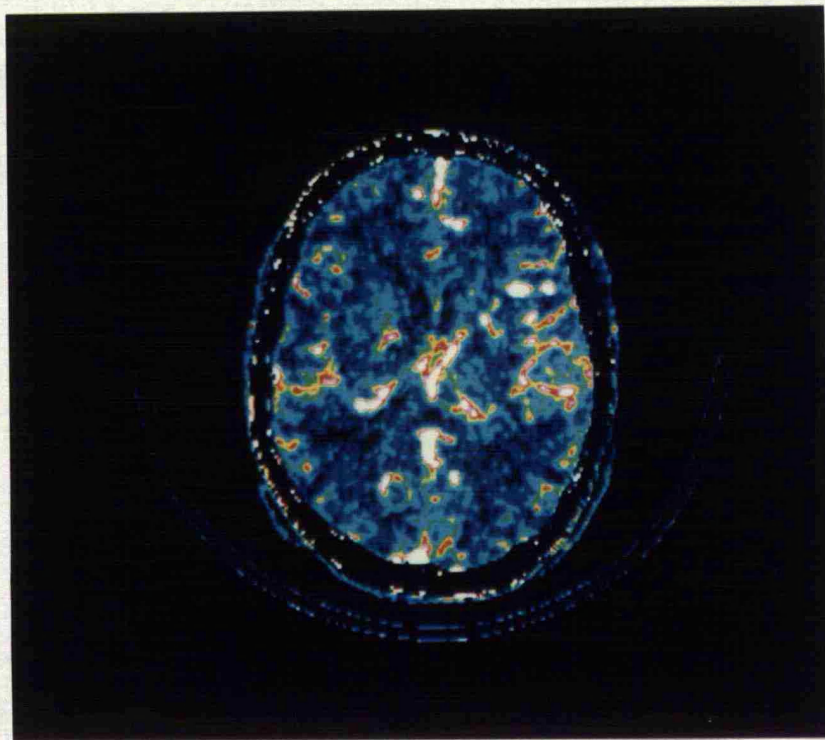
CT perfusion image of the brain in a patient with Moya-moya disease.
